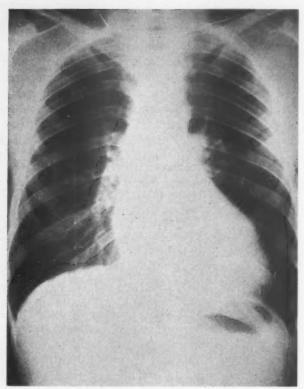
Case 1. Roentgenogram showing left ventricular enlargement.
